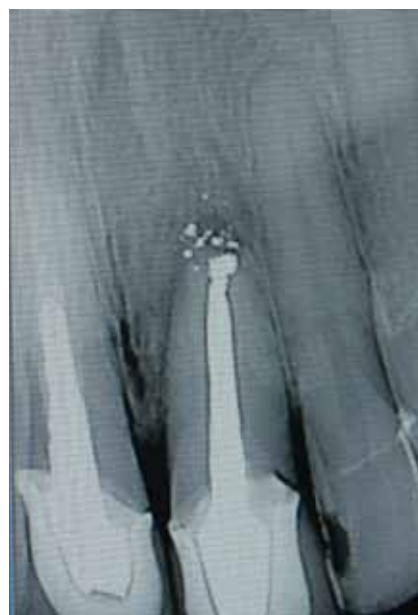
Radiograph of failing upper left central incisor.
